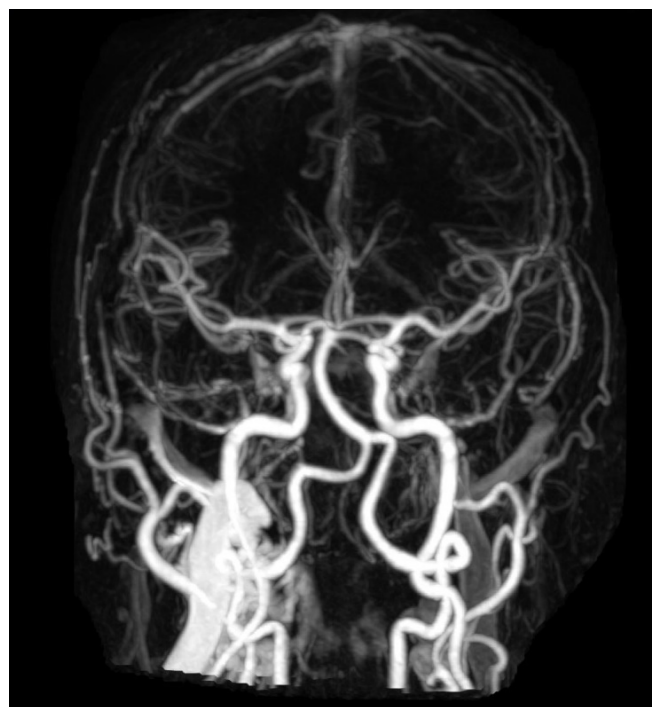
Brain MRI and MRA report and image.
